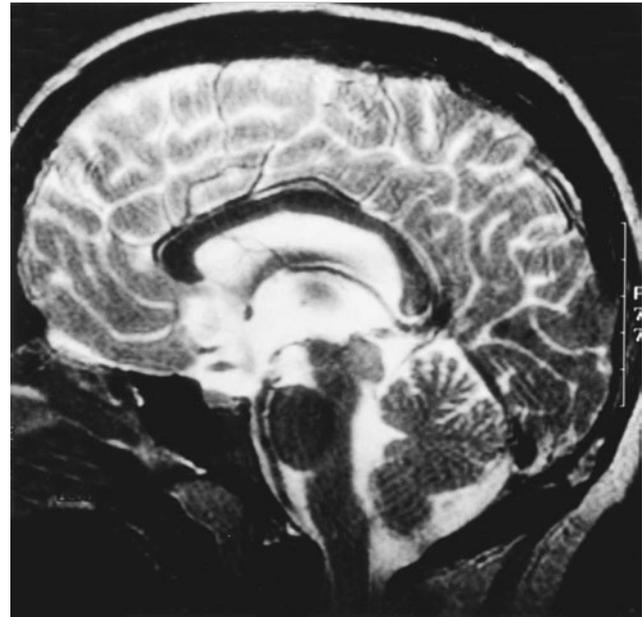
This sagittal T2-weighted magnetic resonance image demonstrates a benign tectal tumor in a child with neurofibromatosis 1 that has remained stable in size for 10 years without specific treatment other than a third ventriculostomy.
